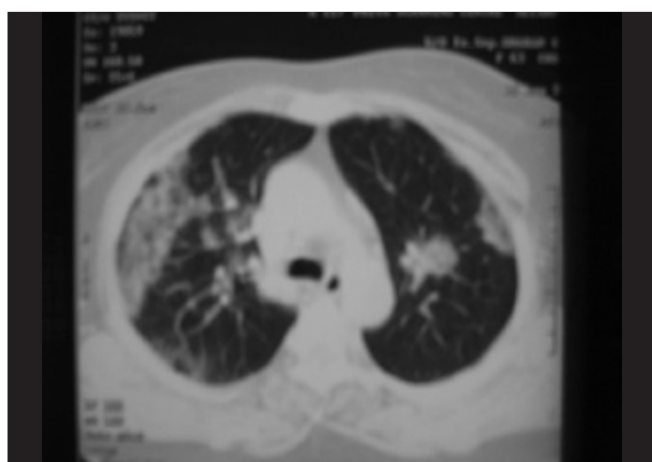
Computed tomography scan chest: Done at 48 hrs of admission, showing confluence of opacities with consolidation
